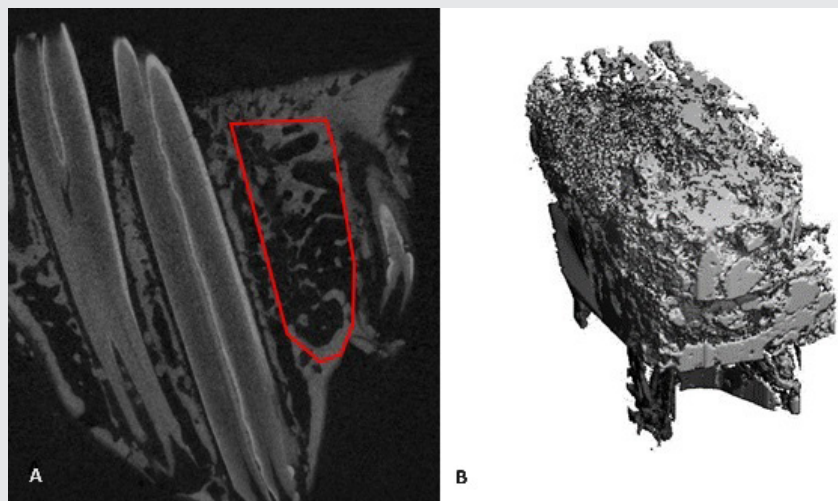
Reconstruction of extraction socket using micro CT image
